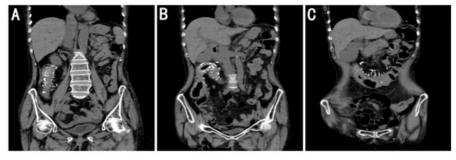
Findings on imaging. A,B,C: Computed tomography revealed showed tortuous thread-like calcifications in the ileocolic vein and right colon vein and middle colon vein, ascending colon wall thickening, edema with calcification.
